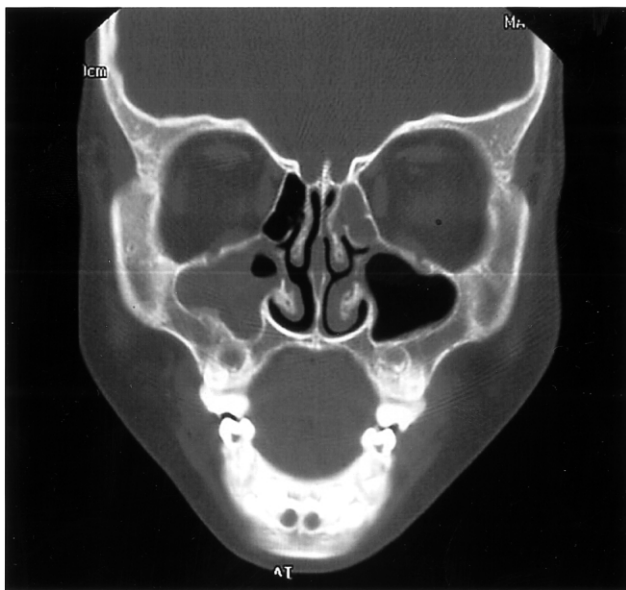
CT scan of sinuses and adenoid showing complete opacification of the left ethmoid and the right maxillary sinuses.
